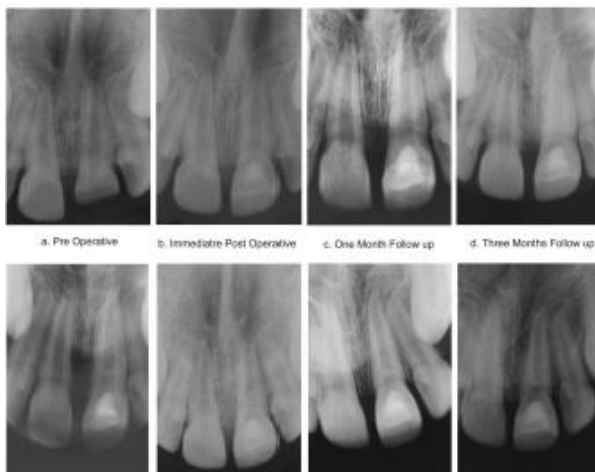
Pre-operative, post-operative and follow-up IOPA radiographs.
